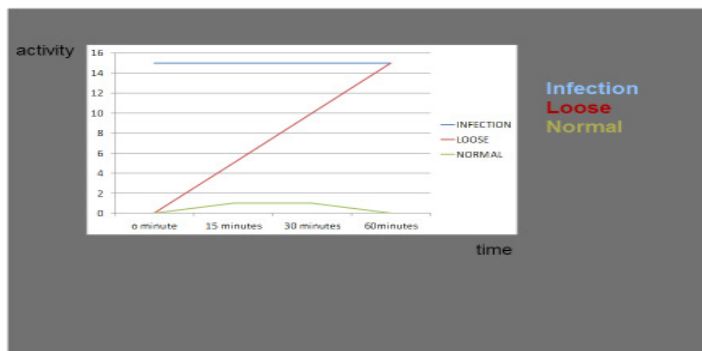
Sequential multiphase pattern of uptake in ¹⁸F-NaF PET-CT in the Dynamic Imaging of Joint Prostheses.
